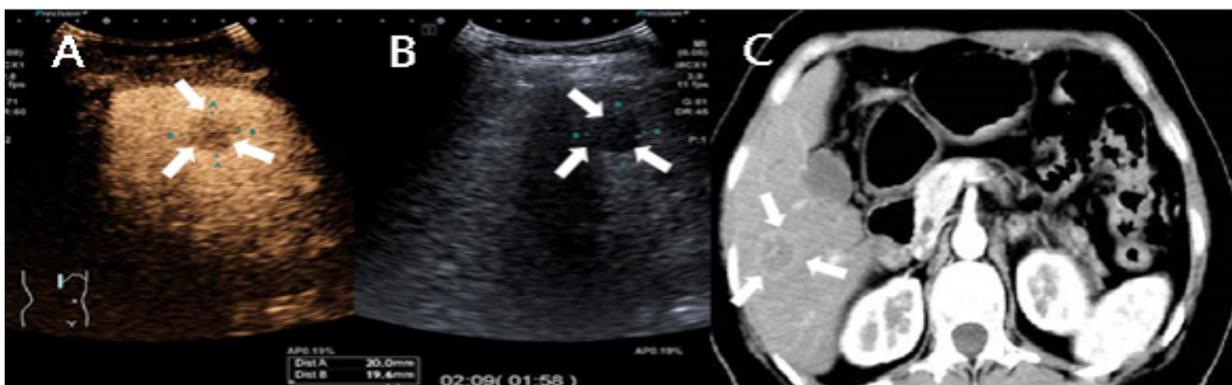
Gastric cancer in a 45-year-old woman. It was pathologically confirmed liver metastases, M1. (A,B). Grey-scale ultrasound revealed a mass in the liver (Figure B arrows), CEUS showed a “black hole” sign in the venous phase of this liver tumor (Figure A arrows). (C). CECT shows a ring-like enhancement in the arterial phase of this liver tumor (arrows). They were both correctly diagnosed as stage M1.
